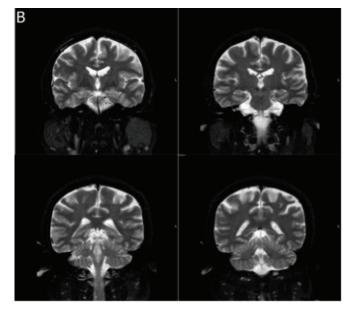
MRI shows left temporal atrophy
